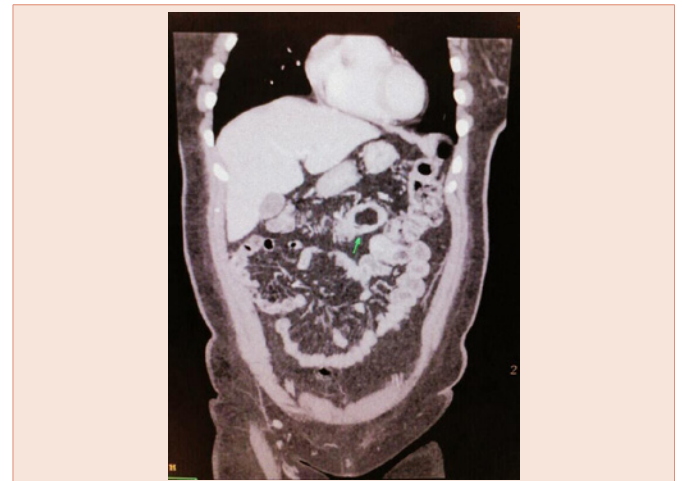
CT scan revealing the location of the lipoma.
